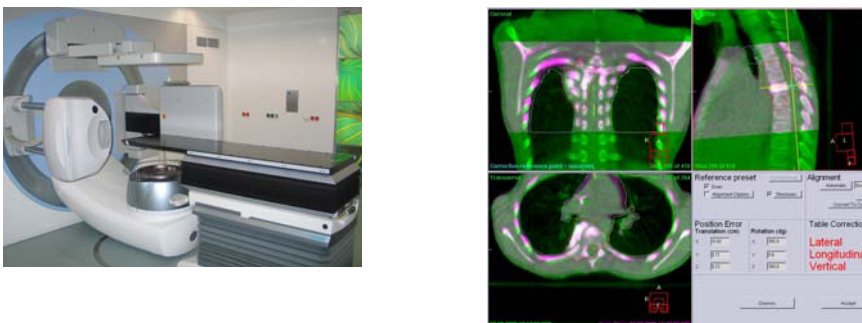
a) Linac with cone-beam CT and robotic hexapod table; b) Rigid body image registration in 6D between CT and CBCT
